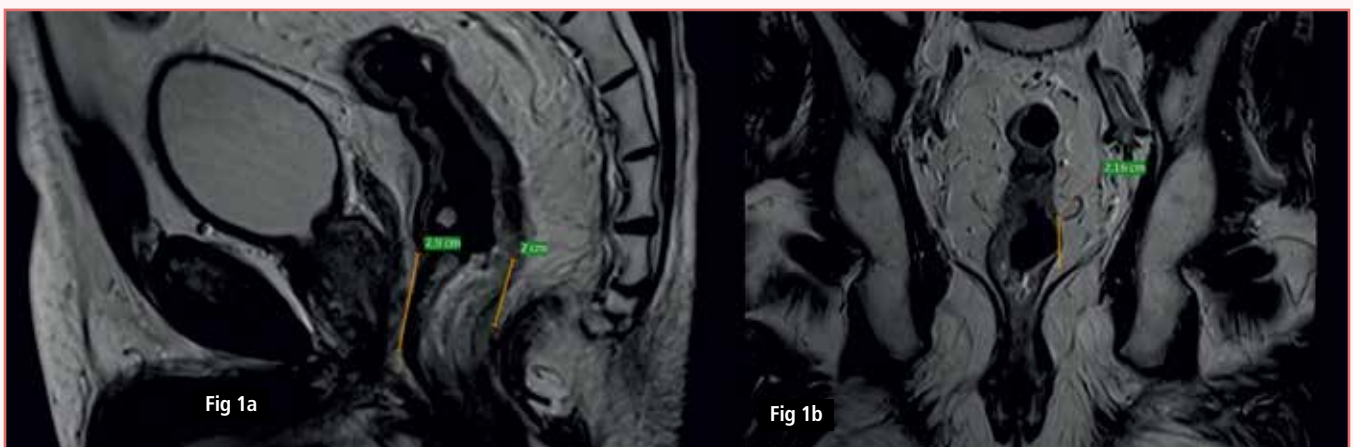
MRI films (Sagittal and Coronal cuts) showing low lying rectal cancer close to anal sphincter complex
